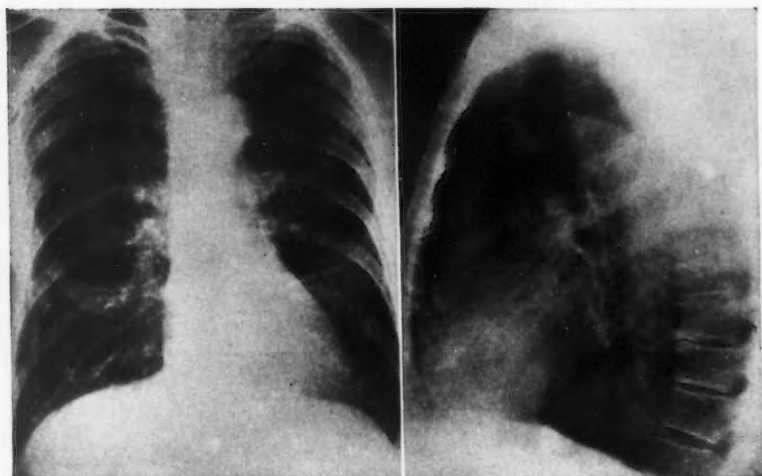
The posteroanterior and lateral roentgenograms of chest reveal no roentgenographic evidence of metastasis.
